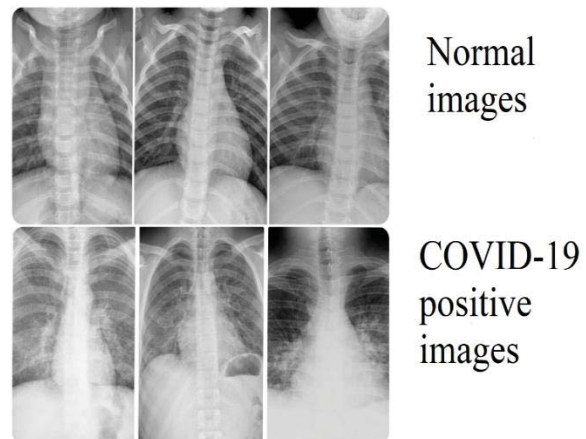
Pictorial representation of chest X-ray images of patients with normal(healthy) and COVID-19.
